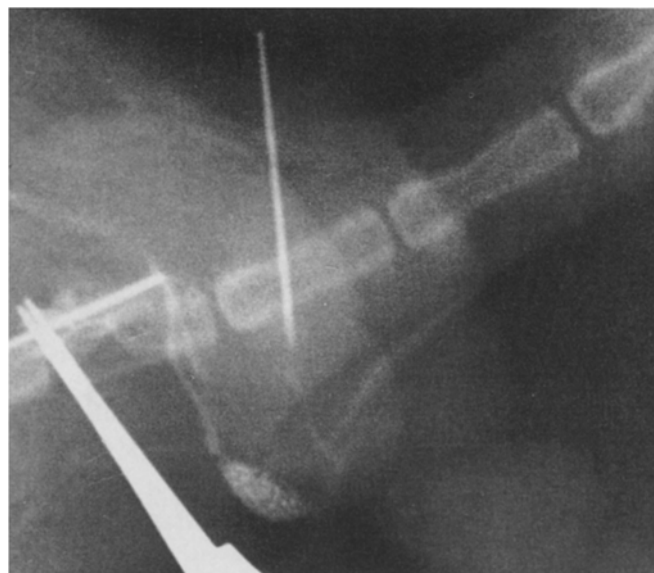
X-radiography examination of a patent anastomosis
